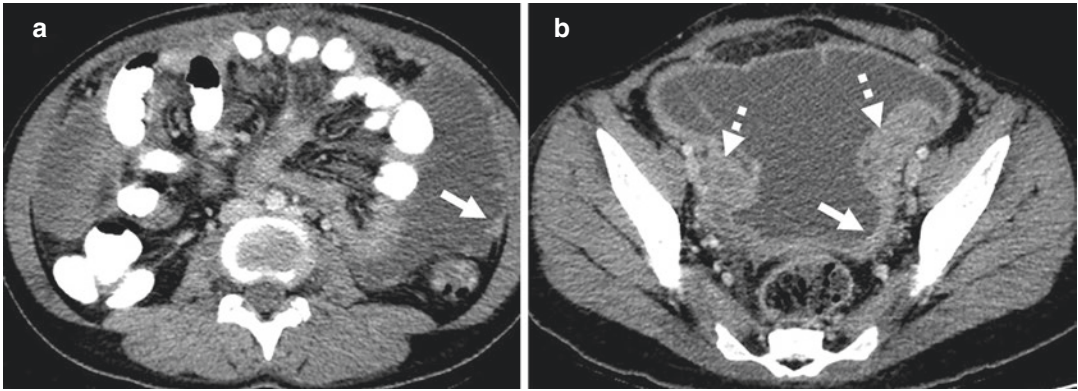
Peritoneal tuberculosis in a 22-year-old woman with abdominal distension for 6 months. (a and b) Axial contrast-enhanced CT images show (a) ascites with peritoneal nodules (white arrow) and (b) diffuse thickening
